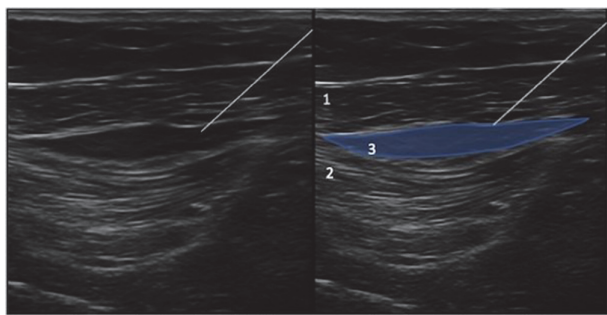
Ultrasonography of suprainguinal fascia iliaca compartment hydrodissection. (1. Iliac muscle, 2. Psoas muscle, 3. Local anesthetic solution).
